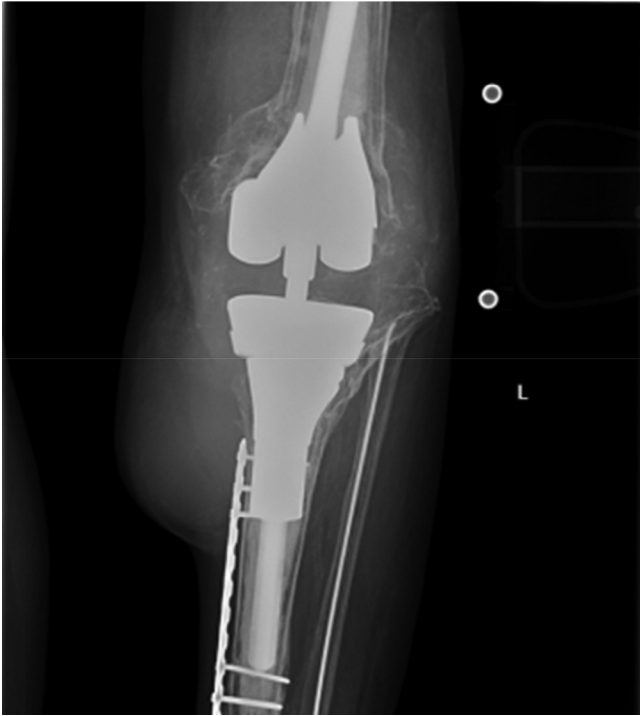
Roentgenogram of the left knee revealing a hinged knee with plate and screws in the tibia as well as intramedullary rod in the fibula.
